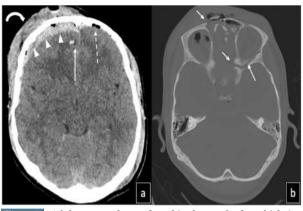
Adolescent male was found in the trunk of a vehicle involved in a MVC while fleeing from border patrol. Axial CT brain window (a) demonstrating extensive intracranial traumatic injury with right frontal subdural hematoma (arrowheads), pneumocephalus (dashed arrow), intraparenchymal hemorrhage (solid arrow) and a right frontal subgaleal hematoma (curved arrow). Axial bone window (b) shows a complex naso-orbital ethmoid (NOE) fracture (solid arrows) with associated discontinuity of the carotid canal (not shown)
